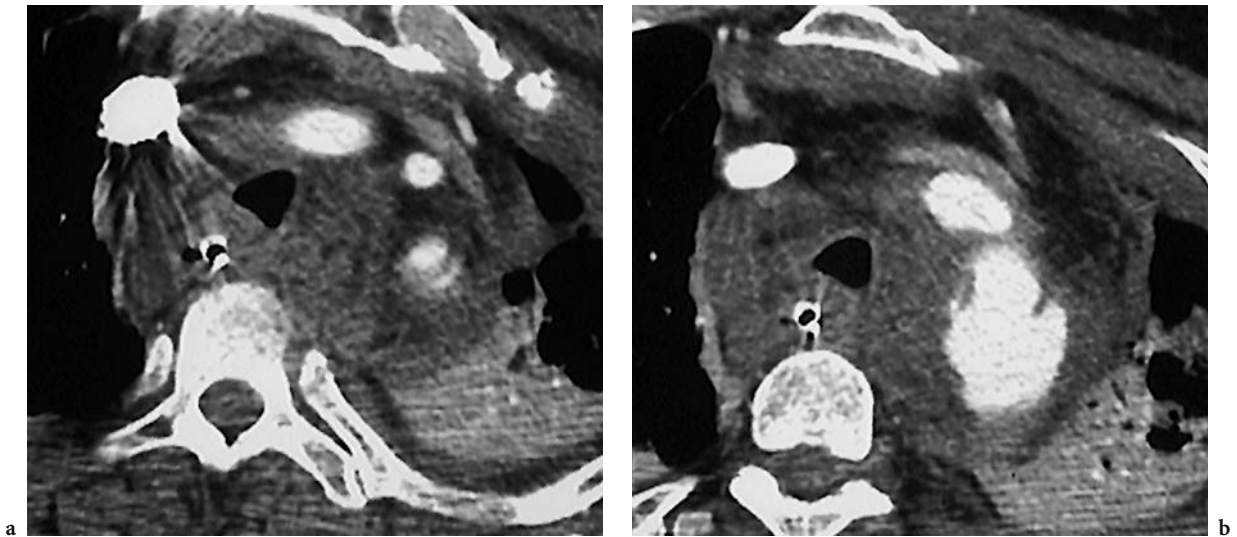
Status after high-speed motor vehicle accident: gross aortic injury. Transverse helical CTA sections demonstrate aortic injury with pseudoaneurysm formation at the aortic isthmus. An intimal injury extends into the left subclavian artery. There is extensive mediastinal hematoma. The findings were confirmed in the operating room
